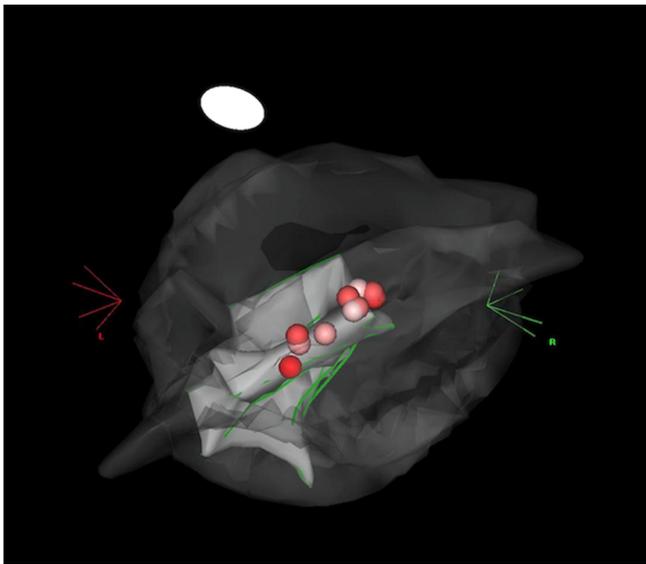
The sites of ablation on the shell constructed by ICE integrated in CARTO system. Red tags show ablation sites. Light gray geometry shows the morphologic RV. Dark gray geometry shows the MB. (ICE: intracardiac echocardiography, RV: right ventricle, MB: moderator band).
